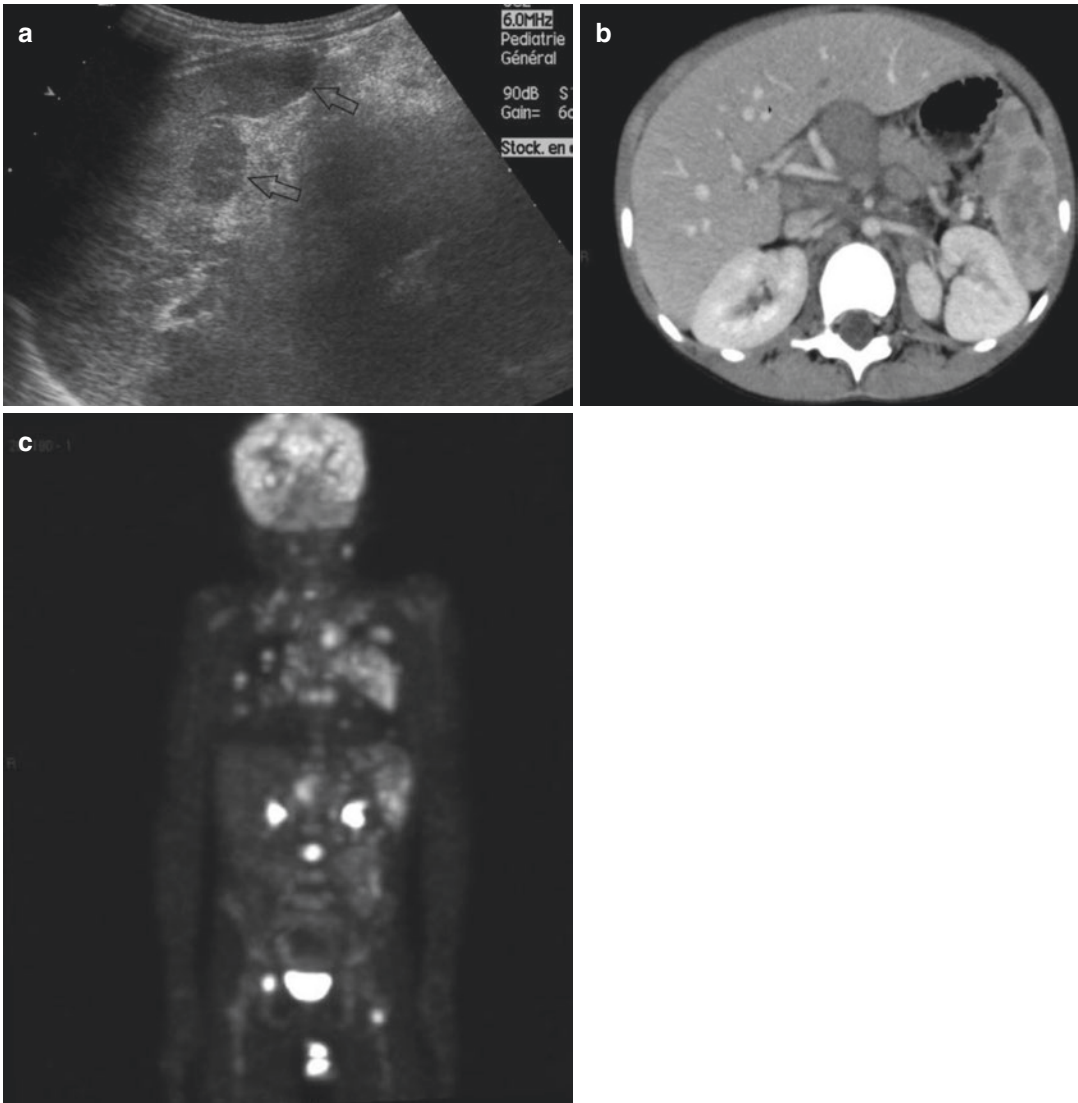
Splenic involvement by lymphoma. (a) US—sagittal view of the *left upper abdomen* (13-year-old boy). The spleen, at its margin, appears nodular and hypoechoic (*arrows*). (b) CE-CT confirms the nodular involvement of the spleen and demonstrates multiple enlarged lymph
